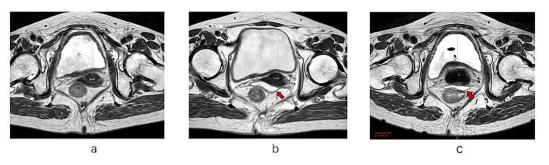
MRI taken before and after hydrogel injection. MRI taken before (a) and after (b) hydrogel injection, with applicator in place (c). The arrow indicates the hydrogel.
